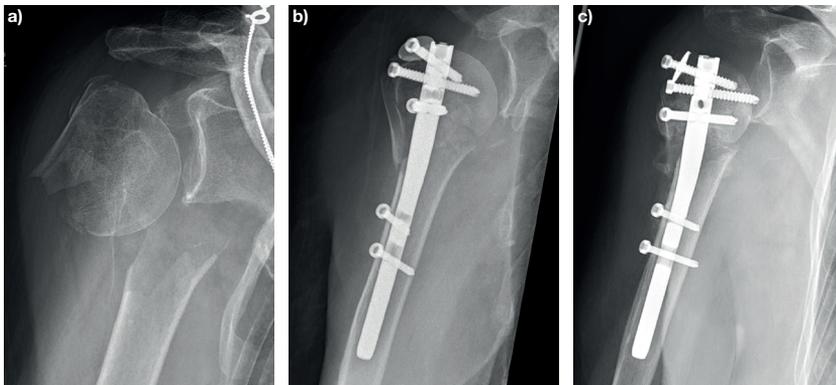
Radiographic example of secondary fracture dislocation with screw cut-out. a) Pre-operative radiograph. b) Post-operative radiograph following fracture fixation with an intramedullary nail. c) Radiograph six weeks post-operative showing secondary displacement of the humeral head fragment with screws penetrating the glenohumeral joint. The patient was reoperated with removal of the proximal screws and the fracture healed.
